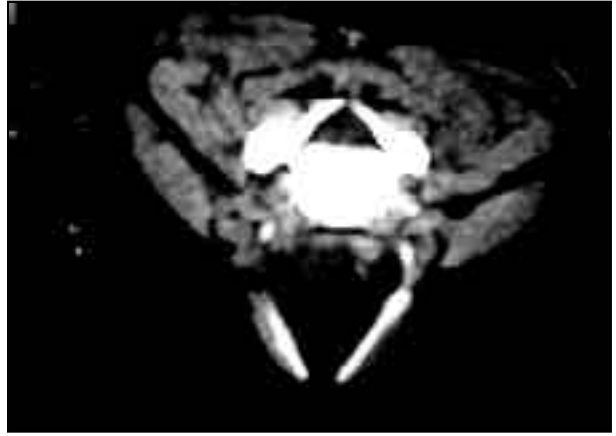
CT Scan of ventricular cyst
